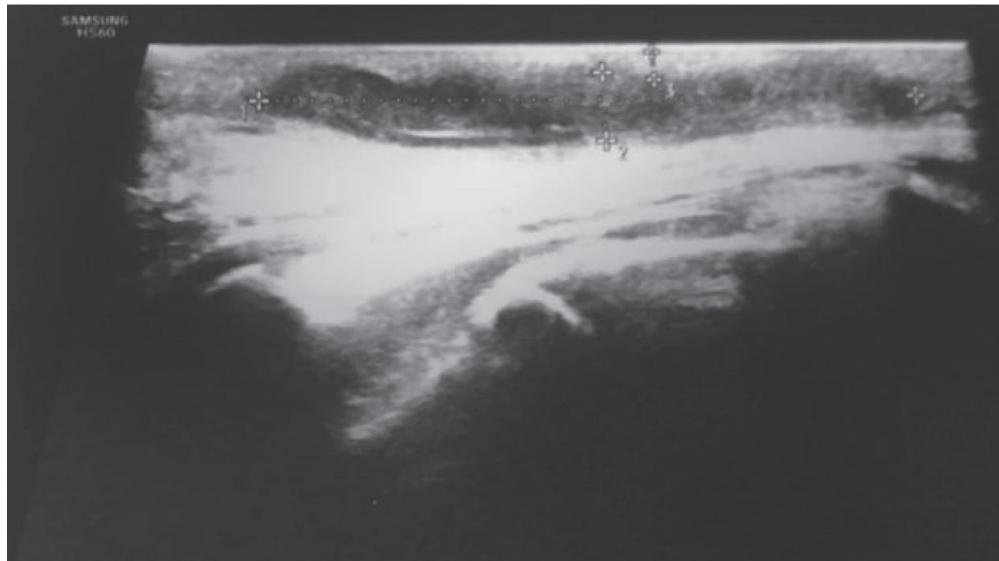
Cavity of pilonidal sinus according to ultrasound
